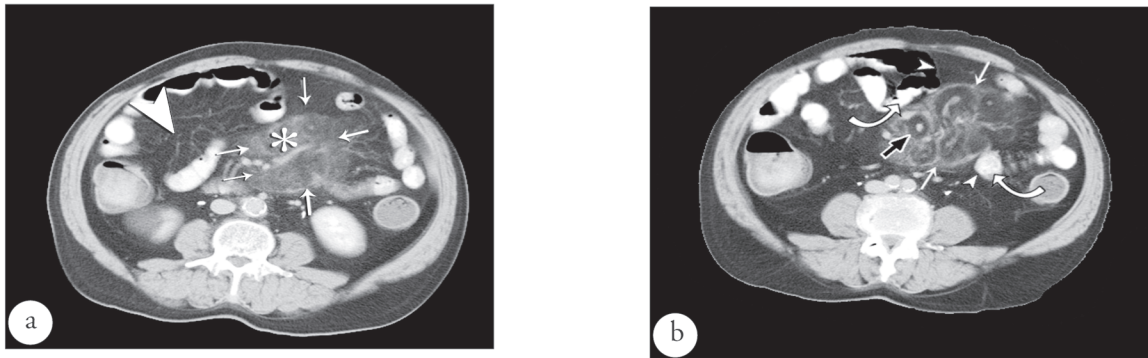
Computerized tomographic findings. a) Axial CT scan of the mid abdomen with intravenous and oral contrast shows a mesenteric mass (arrows). The fatty component of the mass (*) is of a higher attenuation than the rest of the small bowel mesentery (arrow head). b) Another CT image of the mass (white arrows). The lobular contour of the mass is evident. Note the preservation of the fat around the patent mesenteric vessels, what is known as "Fat ring sign" (black arrow). Small bowel loops (curved arrows) are displaced due to the mass but with paper thin walls (arrow heads).
